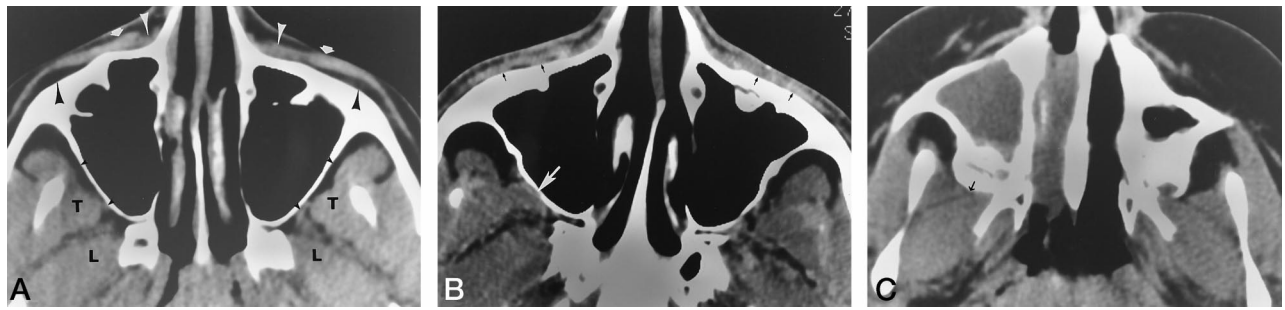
Normal variations in the CT appearance of the periantral soft tissues.
